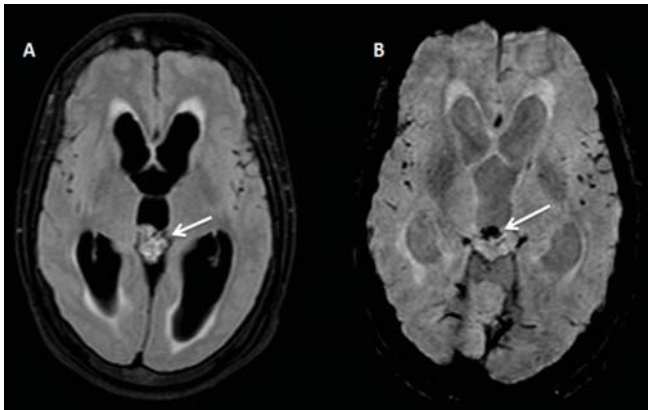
FLAIR weighted axial (A) image shows the hyperintense lesion in the pineal region. Susceptibility weighted axial (B) image shows displaced pineal calcification along the anterior aspect of the lesion.
